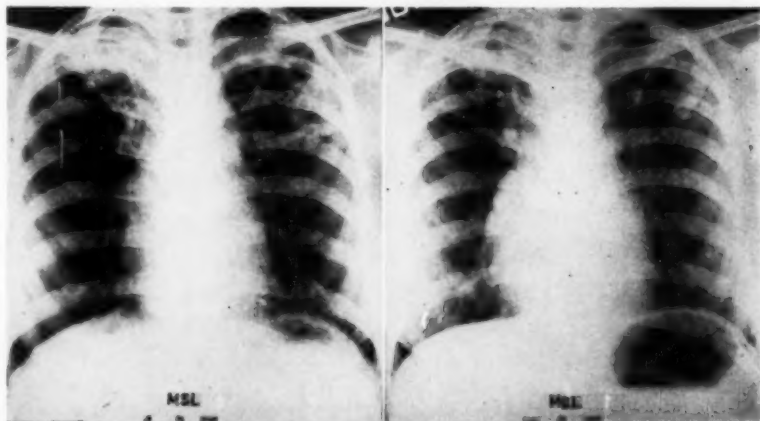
(Case 1): M. S. L., Chest roentgenogram, March 4, 1958. Infiltrative process in superior right lobe and at upper lobe at left where cavitation with fluid level is noticeable.
